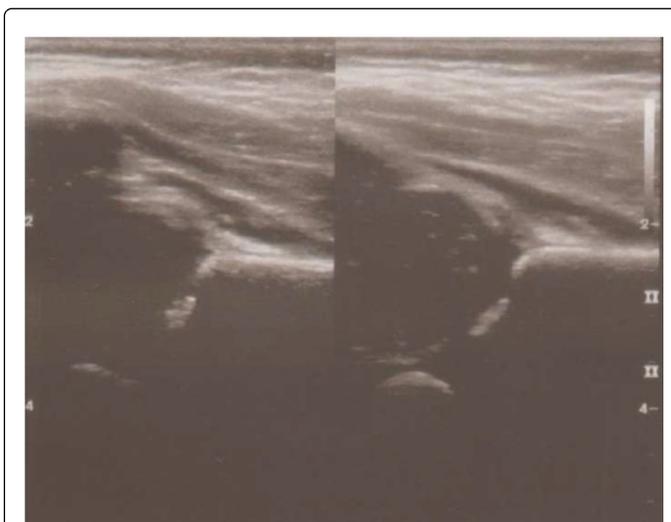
Ultrasound examination after three weeks of stimulation at day 89 of the patient's life. Left and right hip in Graf's scale were rated as IA. The study was conducted on 15.01.2015.
